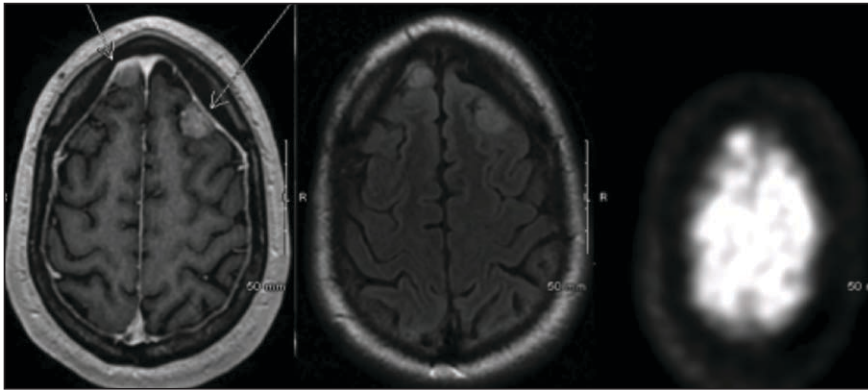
MRI of brain with and without contrast (left and center). Two new enhancing extra-axial right frontal and left frontal mass lesions are identified by arrows, likely representing dural-based metastatic deposits. A PET scan (right) of the same region demonstrates increased uptake in the left frontal lobe.
